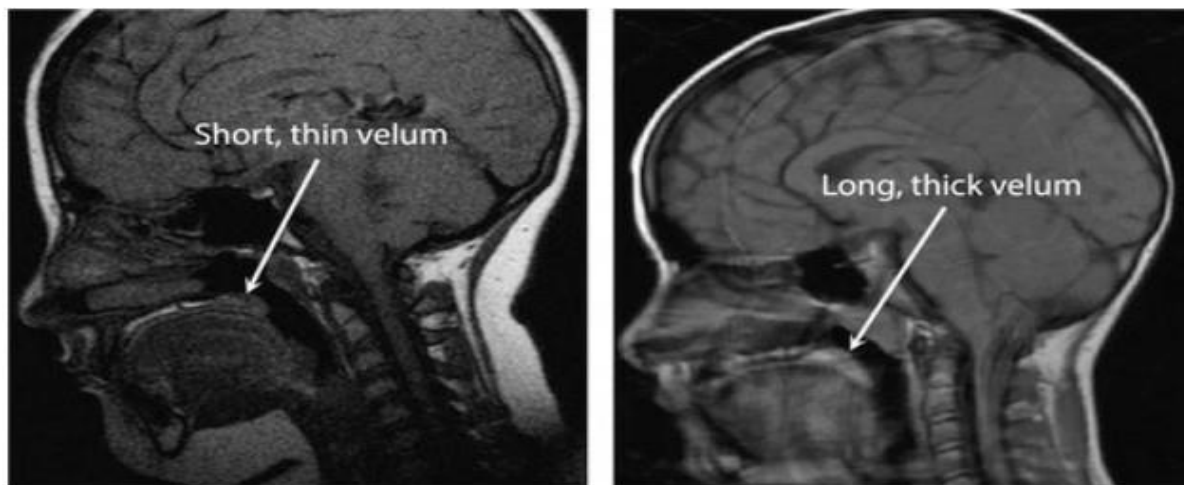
MRI Comparison of Velar Length and Thickness in Two Individuals. Reproduced from Kollara et al. (2017) under Creative Commons Attribution (CC BY 4.0) license.
